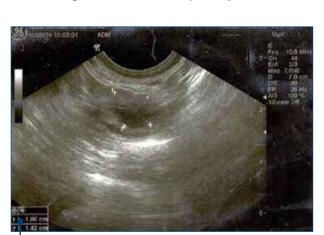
Ultrasonographic aspect of a dominant follicle in day 12 of menstrual cycle (diameter 16.3 mm)
